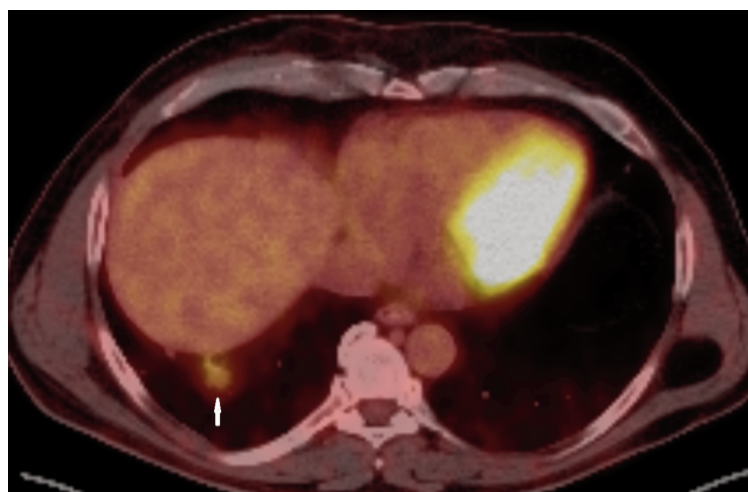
Positron Emission Tomography (PET/CT) shows high Fluorodeoxyglucose (FDG) uptake in the lesion.
